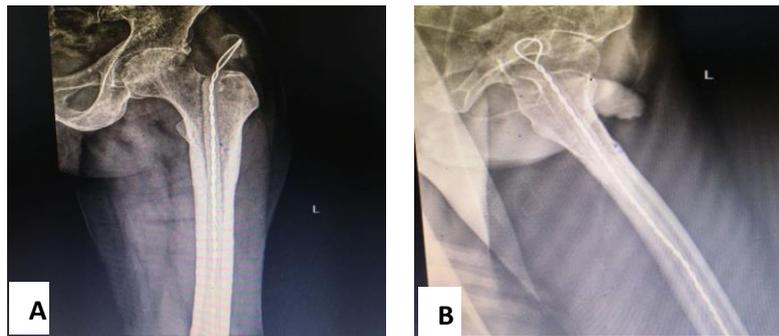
A. Post-operative Antero-posterior; Lateral B. plain X-Rays showing Indigenous Antibiotic Impregnated PMMA Cement Rod in situ
